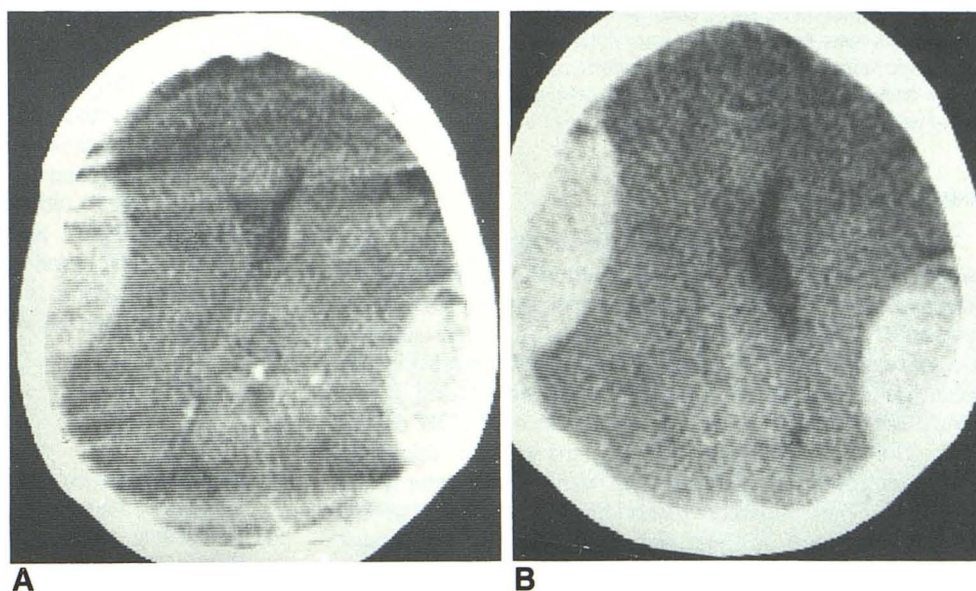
Case 1. Nonenhanced CT scans. A and B, Bilateral biconvex acute subdural hematomas without significant anterior and posterior extension. Note small hypodense region in superior part of hematoma with fluid level.
